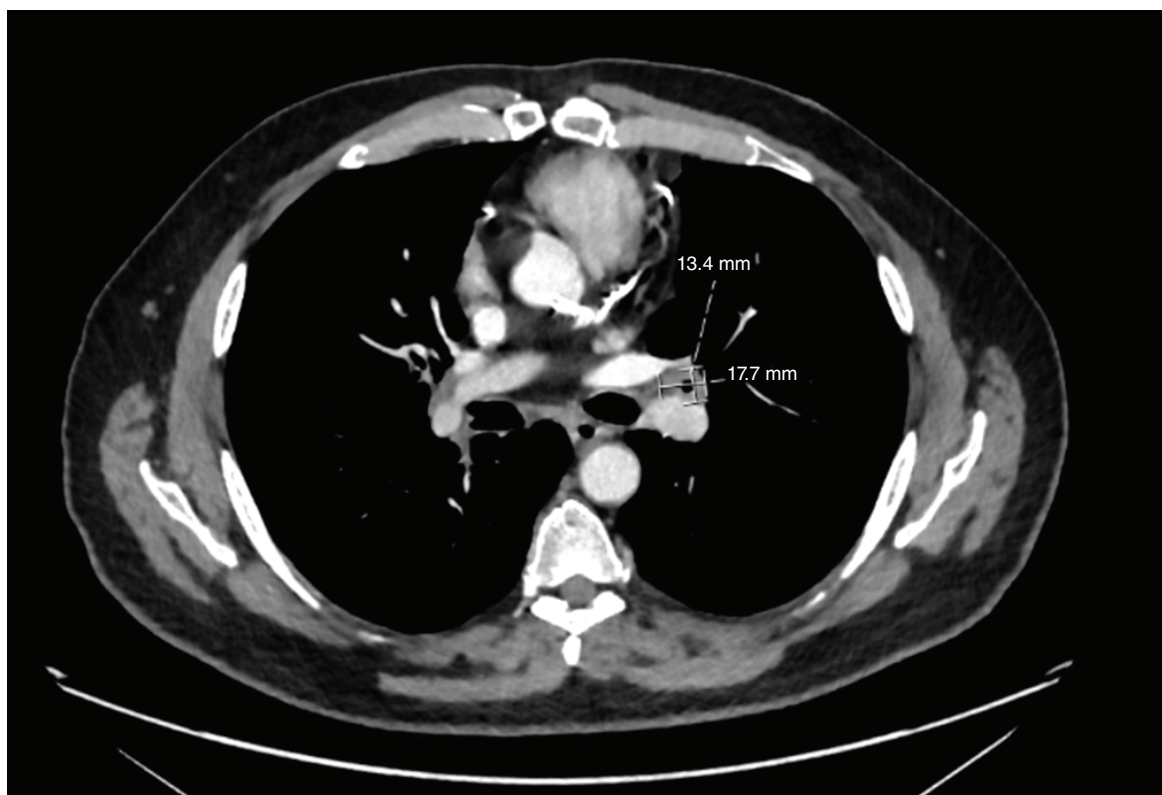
Computed tomography chest from May 2022 showing new proximal thickening of the left upper lobe.
